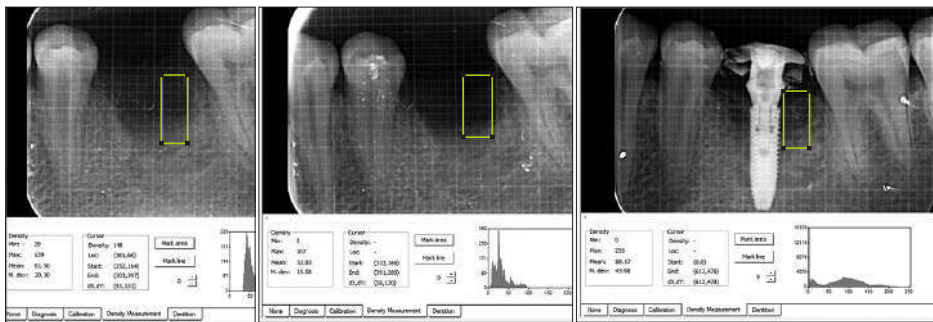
Intra-oral periapical radiographic images for assessment of bone formation and density using Digora software. Vivekanand Sabanna Kattimani et al: Socket preservation using eggshell-derived nanohydroxyapatite with platelet-rich fibrin as a barrier membrane: a new technique. J Korean Assoc Oral Maxillofac Surg 2019
